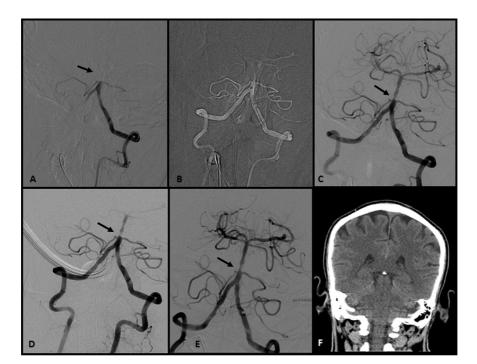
A 59 years old male, a known diabetic presented with left hemiparesis and slurring of speech on wake up with National Institutes of Health Stroke Scale (NIHSS) of 11. Imaging showed mid basilar occlusion with diffusion-weighted imaging (DWI) posterior circulation Alberta Stroke Program Early Computed Tomography Score (Pc-ASPECTS) of 8. (A) (arrow) Mid basilar artery occlusion for which underwent mechanical thrombectomy (B) using modified Solumbra technique achieving modified Thrombolysis in Cerebral Infarction (mTICI) 3 recanalization with underlying residual stenosis (arrow, C). Check angiogram after a few minutes showing new thrombi formation with slowing of forward flow and impending reocclusion (arrow, D). Intra-arterial tirofiban was administered, resulting in improvement of luminal caliber with the good forward flow (arrow, E). Twenty-four hours' follow-up computed tomography (CT) showed no evidence of hemorrhage (F). The patient was functionally independent with a modified Rankin Scale (mRS) score of 1 at 3 months' follow-up.
